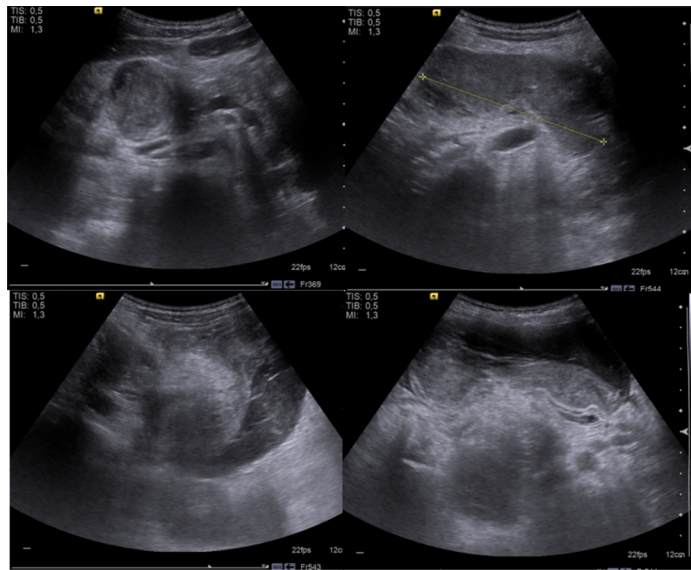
Abdominal ultrasound reveals elongated collection, measuring 12 cm x 5 cm (LxAP) with heterogeneous echogenic content and fluid/fluid level, located anteriorly to the pancreas.
